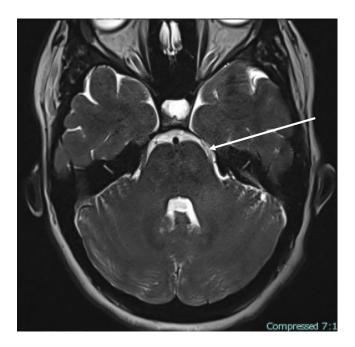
A thin slice axial T2 MRI of the cerebellopontine angle shows atrophic left cisternal trigeminal nerve.
